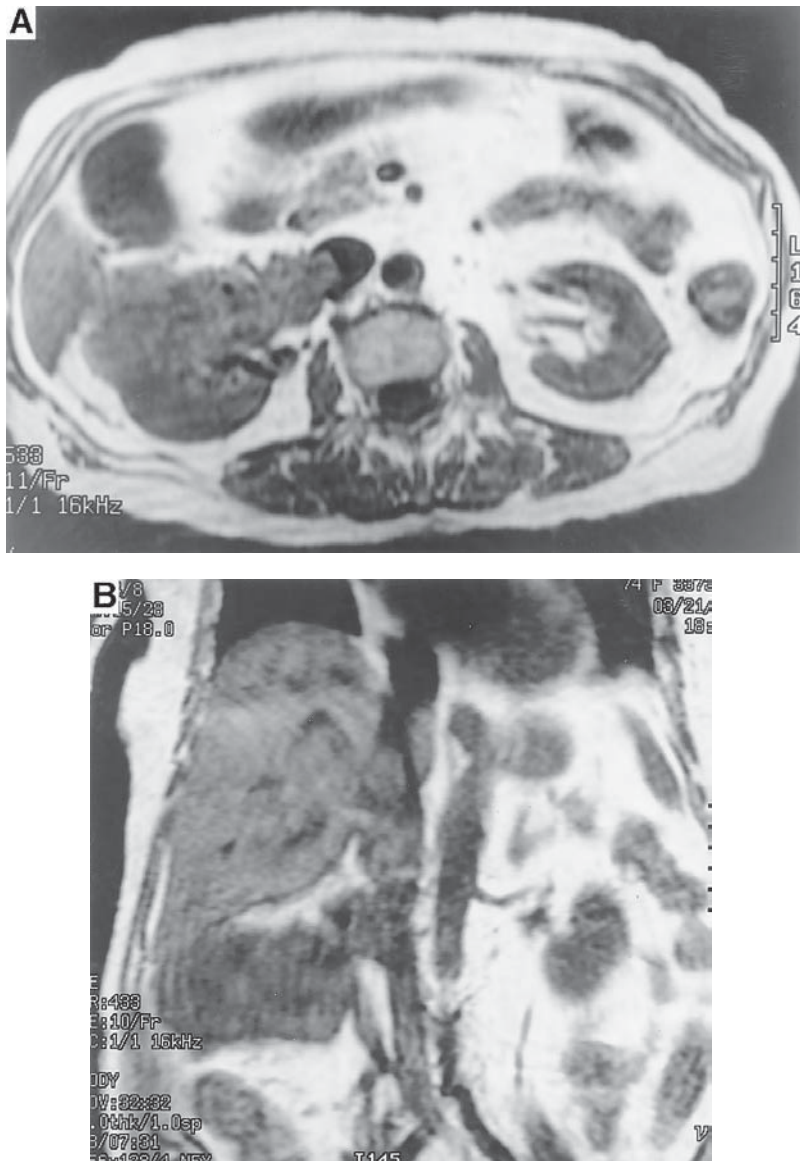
MRI of a patient with tumor thrombus in the inferior vena cava (IVC). Transverse projection (A) showed thrombus projecting into the lumen of the IVC. Coronal projection (B) defined the cephalad extent of the thrombus.
